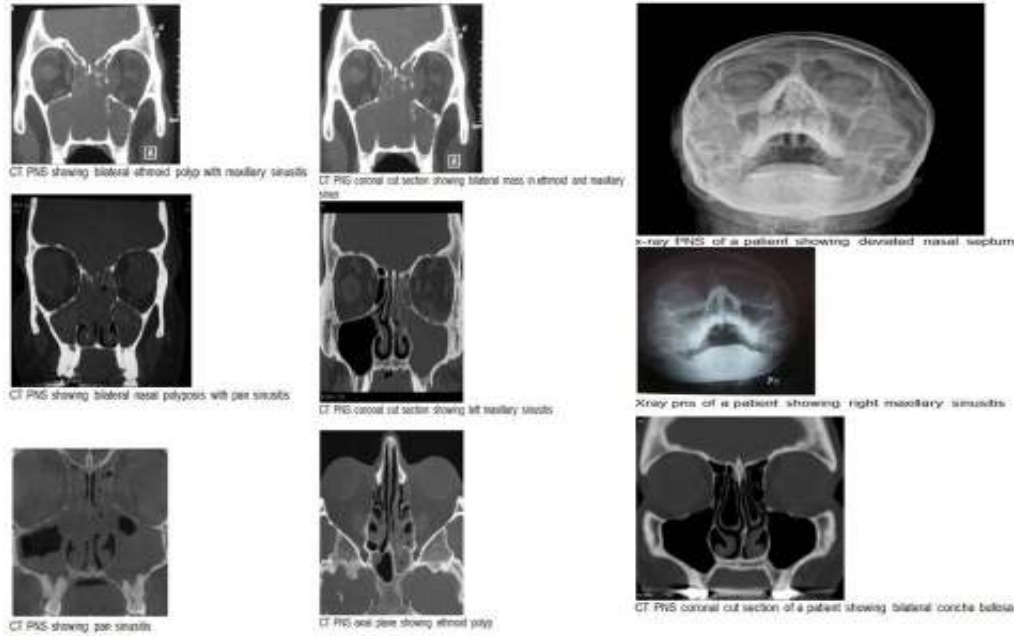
CT PNS and X-ray
